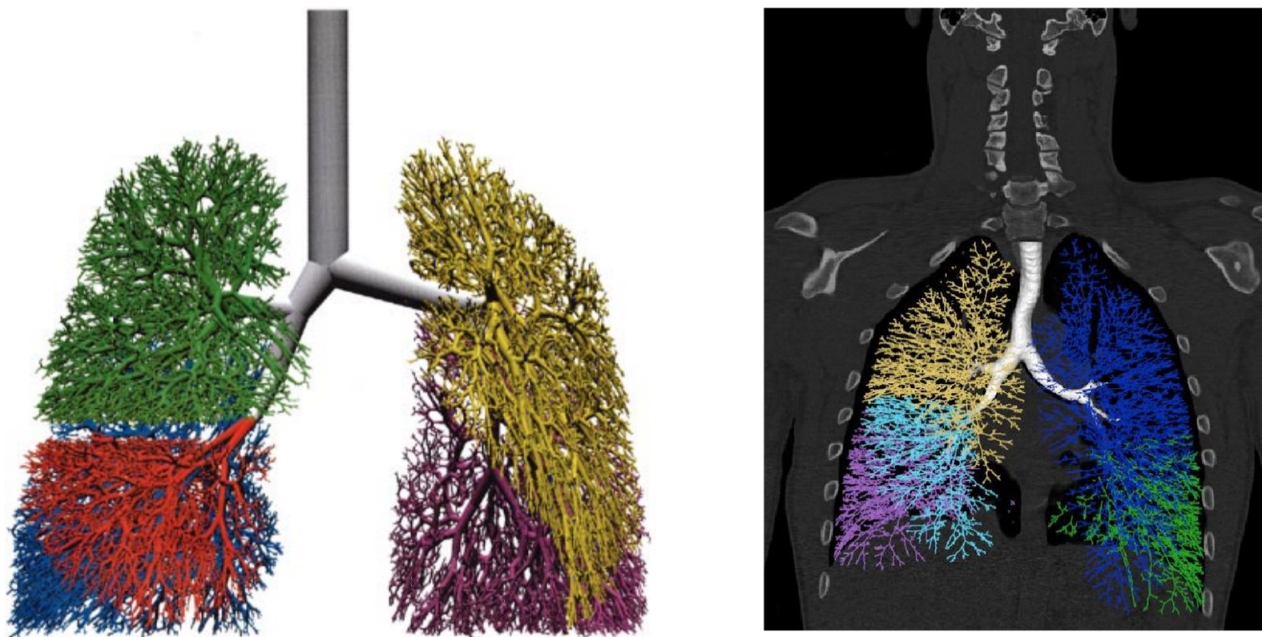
Left: Idealized geometry of the tracheo-bronchial tree generated by a tree generation algorithm. The colors correspond to the different lobes of the lungs where the airways are contained. Taken from [131]. Right: Geometry of the tracheo-bronchial tree coupling HRCT-scan images (white region) and tree generation algorithm (colored regions). Taken from [109].
